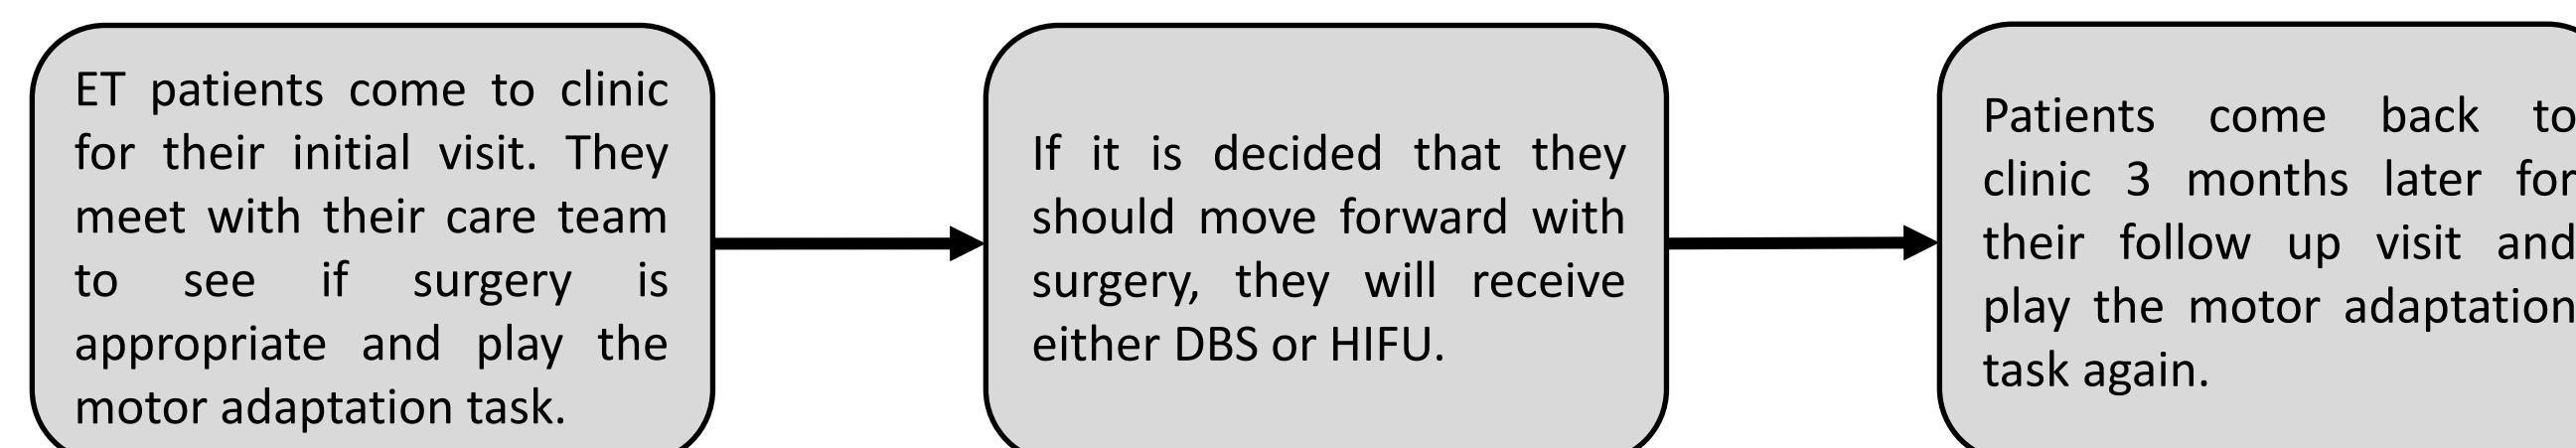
Experimental timeline for ET patients playing the motor adaptation task and receiving deep brain stimulation (DBS) or high intensity focused ultrasound (HIFU).
